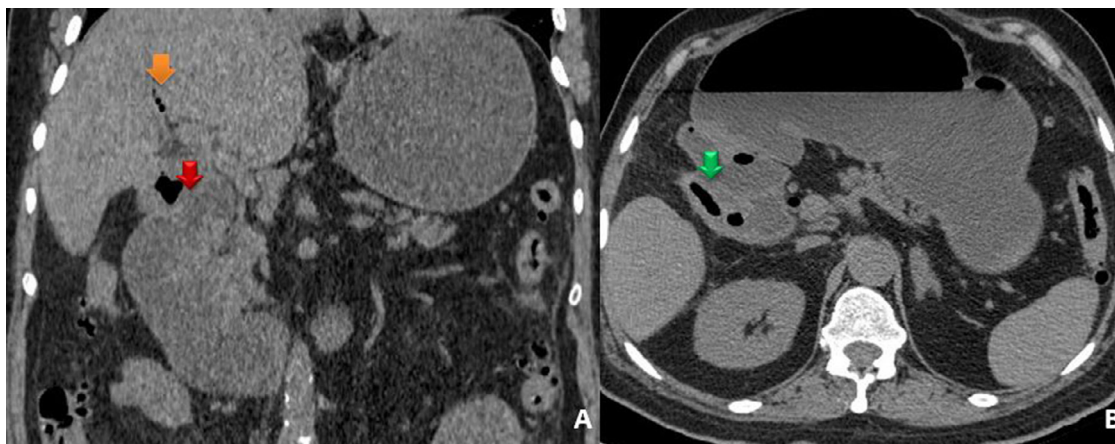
Abdominal CT scan without contrast enhancement in coronal and axial planes. (A) Connecting path between the gallbladder and duodenum: cholecystoduodenal fistula (Red arrow), Air in the biliary tree is also seen (Orange arrow). (B) Collapsed gallbladder with thickened walls and intraluminal air (Green arrow). (Color version of figure is available online.)
